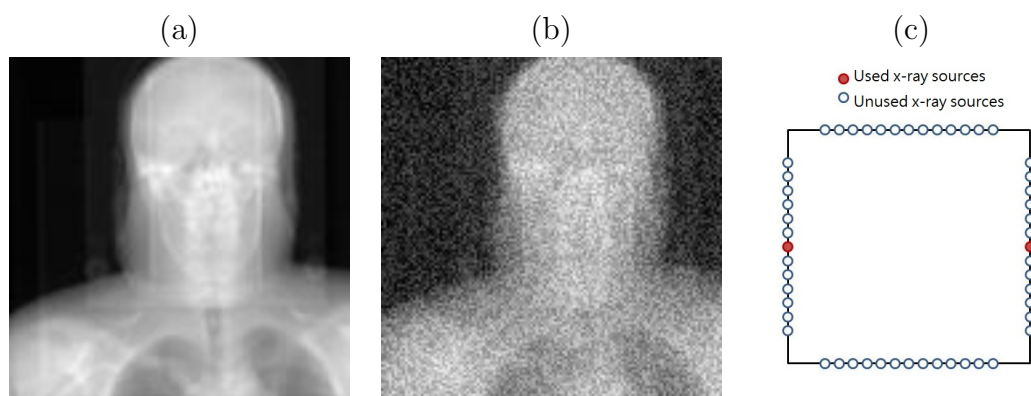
(a) A raw DRR from a x-ray source in the NST (b) DRR with Gaussian noise added (c) the NST geometry of two opposing x-ray sources
